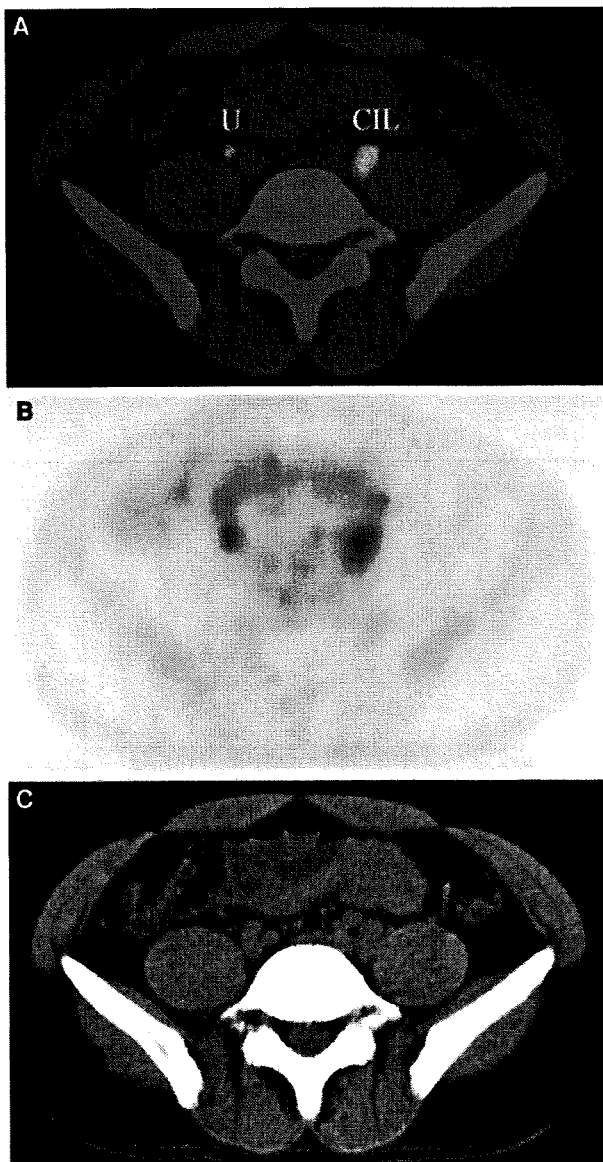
Axial noncontrasted PET/CT image (A), PET (B), and CT (C) shows enlarged common iliac lateral lymph nodes with increased uptake in patient with follicular lymphoma. Focal uptake of ureter mimics abnormal uptake of common iliac lateral lymph node. CIL, common iliac lateral lymph node and U, ureter.
